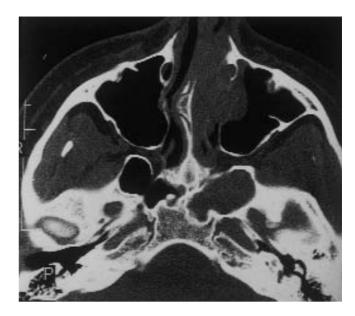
CT scan demonstrated non-specific opacity in the left nasal cavity, the maxillary and sphenoid sinuses.
